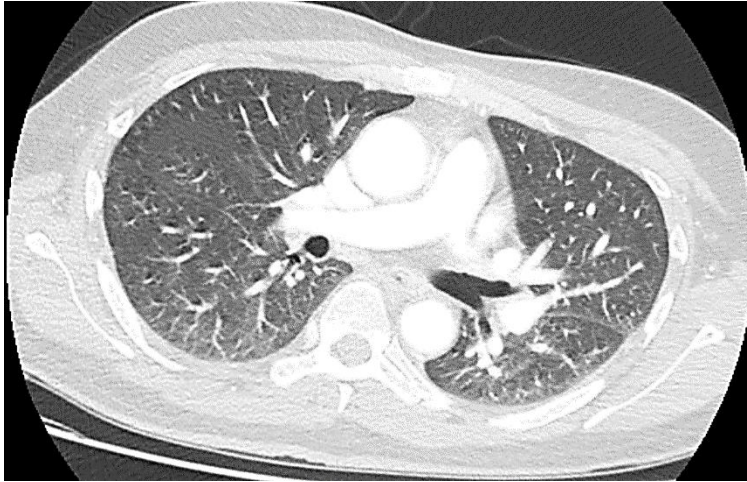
CT image of the chest
